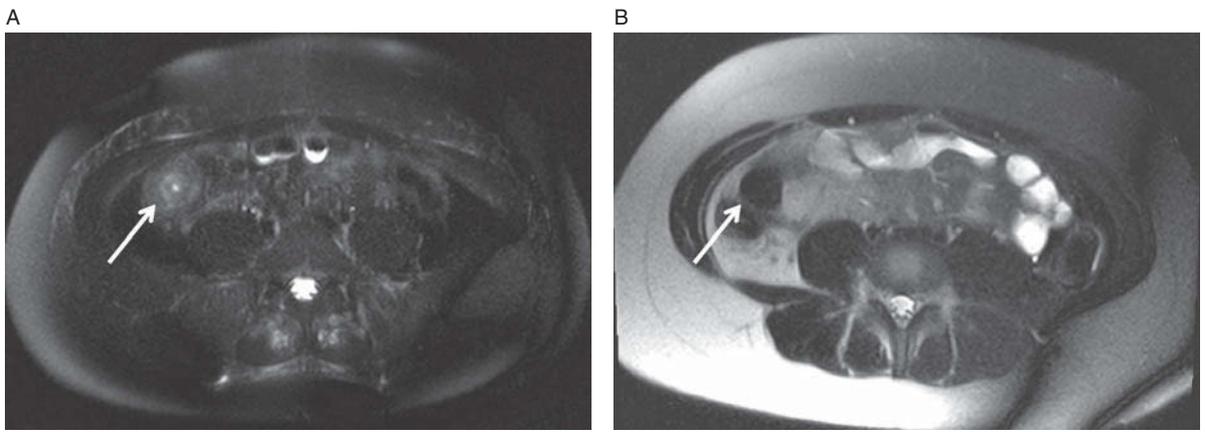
Active Crohn's disease. Axial T2-weighted image (A) shows a thickened terminal ileum with increased T2-signal within the wall (arrow) indicative of active disease. Axial T2-weighted image (B) from same patient 6 weeks following initiation of anti-TNF therapy. The terminal ileum remains thickened, but the active changes are gone. (Note also the technical difference between the two images. In image B the fat-saturation failed.)
